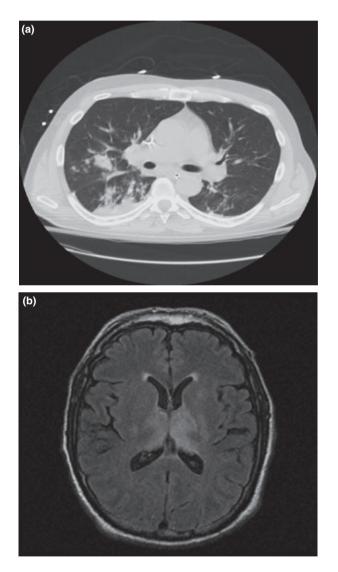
Computed tomography scan of the chest (a) showing infiltrates and magnetic resonance images of the brain (b) (fluid-attenuated inversion recovery, FLAIR signal) showing bilateral symmetrical involvement of thalami.
